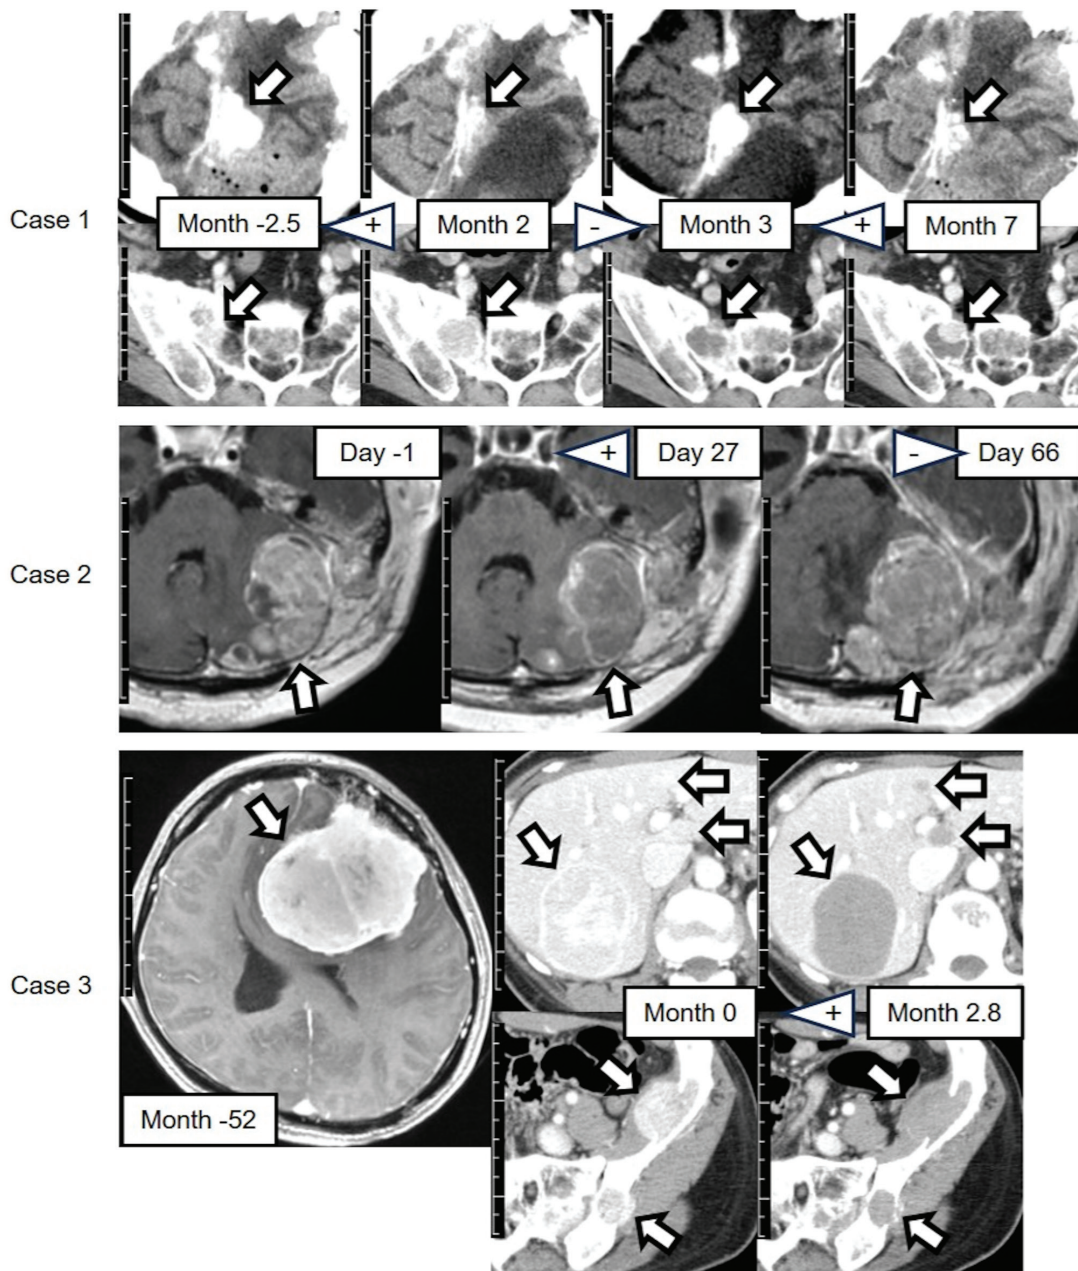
Contrast-enhanced CT or head T1-weighted images of the 3 cases. The arrows indicate the representative tumors. The months or days indicate the time since initiation of pazopanib treatment. + indicates initiation or resumption of pazopanib treatment; - indicates interruption of pazopanib treatment. Scale bar, 1 cm per division. Case 1: Upper row, left supratentorial falx tumors, head CT; lower row, right sacral tumor, pelvic CT. Case 2: T1-weighted images showing left infratentorial tumors. Case 3: Upper row, liver tumors, abdominal CT; lower row, left iliac tumors, pelvic CT; contrast-enhanced head T1-weighted image shows the initial primary tumor with no recurrence after resection. The image was provided by a previous institute, whose imaging equipment and conditions differed from those described in Appendix S1. CT, computed tomography.
